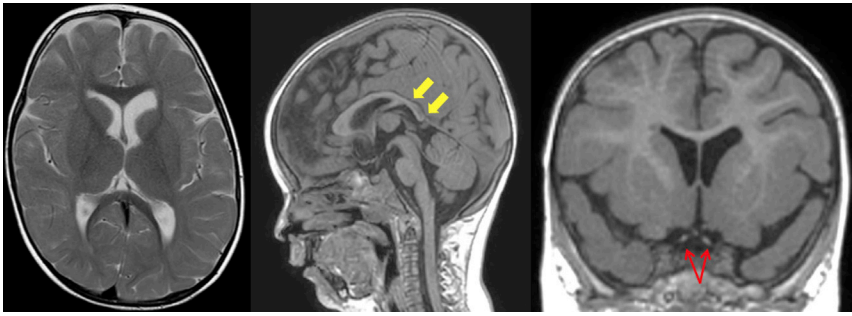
Brain MRI Scan of Individual 1, Who Harbors a *De Novo* VAMP2 p.Ser75-Pro Variant, at the Age of 2 Years
